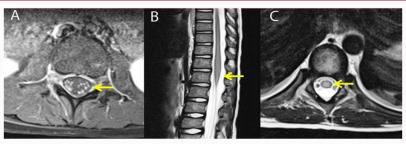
MRI spine: (A) Contrast-enhanced T1-weighted axial sections showing cauda-equina nerve-root enhancement (arrow), (B) T2-weighted sagittal and (C) axial sections showing central hyperintensity (arrow) in thoraco-lumbar cord suggestive of myelitis.
